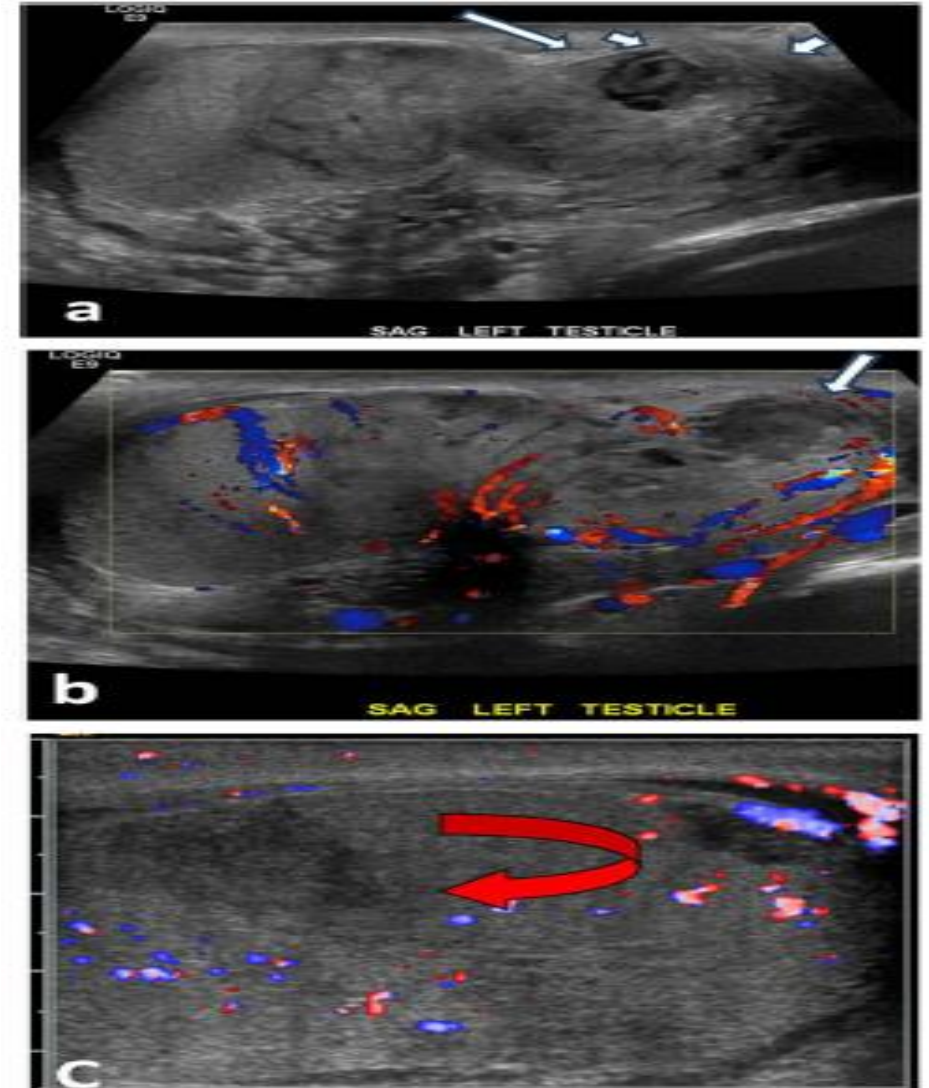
Testicular rupture and fracture. a Contour abnormality of the lower pole of the testis with protrusion of the testicular parenchyma (short arrow) through the ruptured tunica albuginea (long arrow). b Corresponding Colour Doppler image demonstrates avascularity in the extruded testicular tissue (arrow). Features indicate testicular rupture. c A linear, hypoechoic area through the testicular parenchyma with absent vascularity in another patient status post testicular trauma representing testicular fracture (curved arrow)
